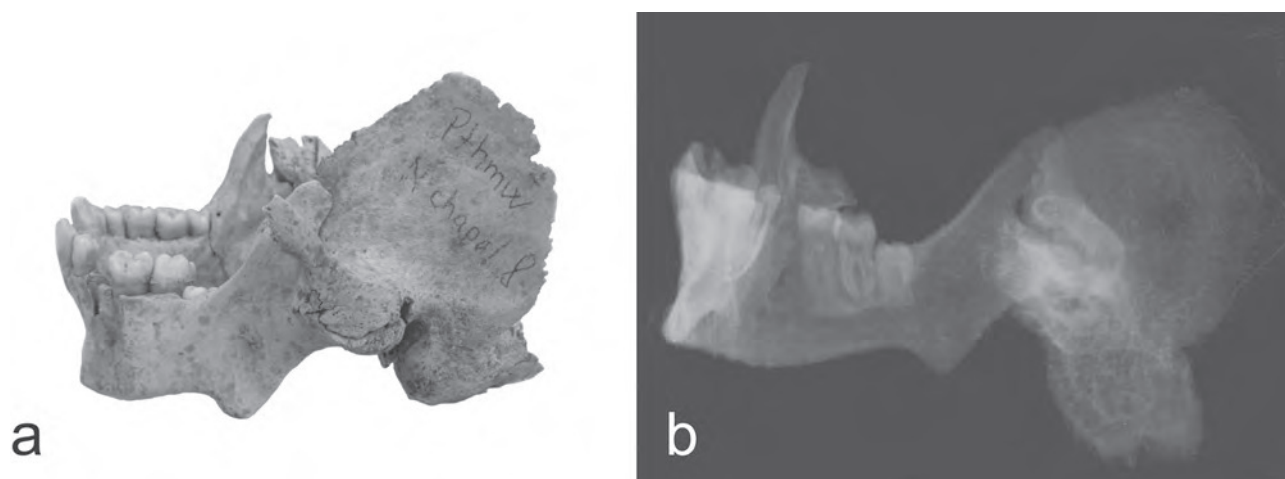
a) View to the left temporomandibular joint with ankylosis; b) X-ray photograph of affected temporomandibular joint. (Tomb of Ptahemwia, New Kingdom Necropolis, Saqqara, Egypt). Photo by L. Horáčková. X-ray by Salima Ikram, American University Cairo.
